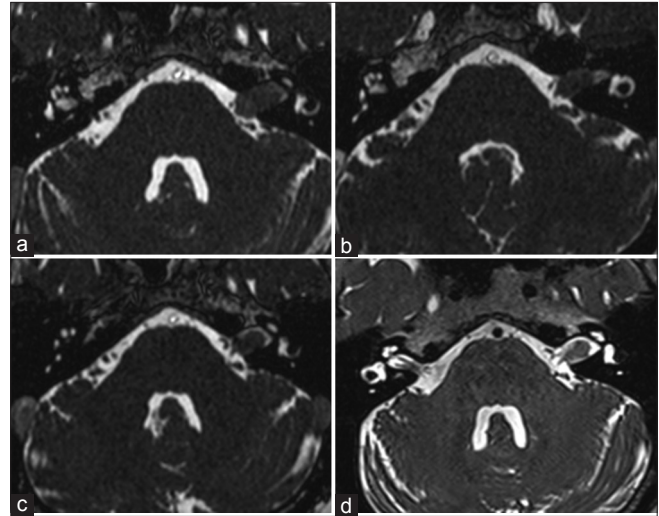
T2-weighted images showing gradual tumor shrinkage. (a) The solid and nodular tumor on the left cerebellopontine angle cistern expanded the internal auditory canal. (b) Tumor shrinkage was seen at 1-year follow-up. (c) Peritumoral cerebrospinal fluid was observed at 2-year follow-up. (d) The solid tumor involuted at 3-year follow-up.
